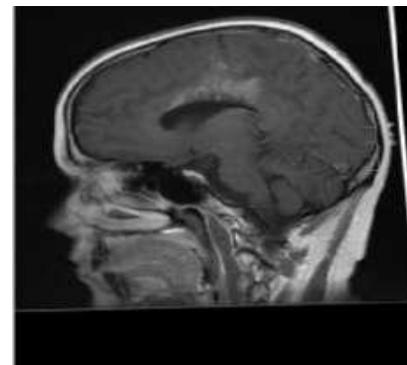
Registered MRI image Image
